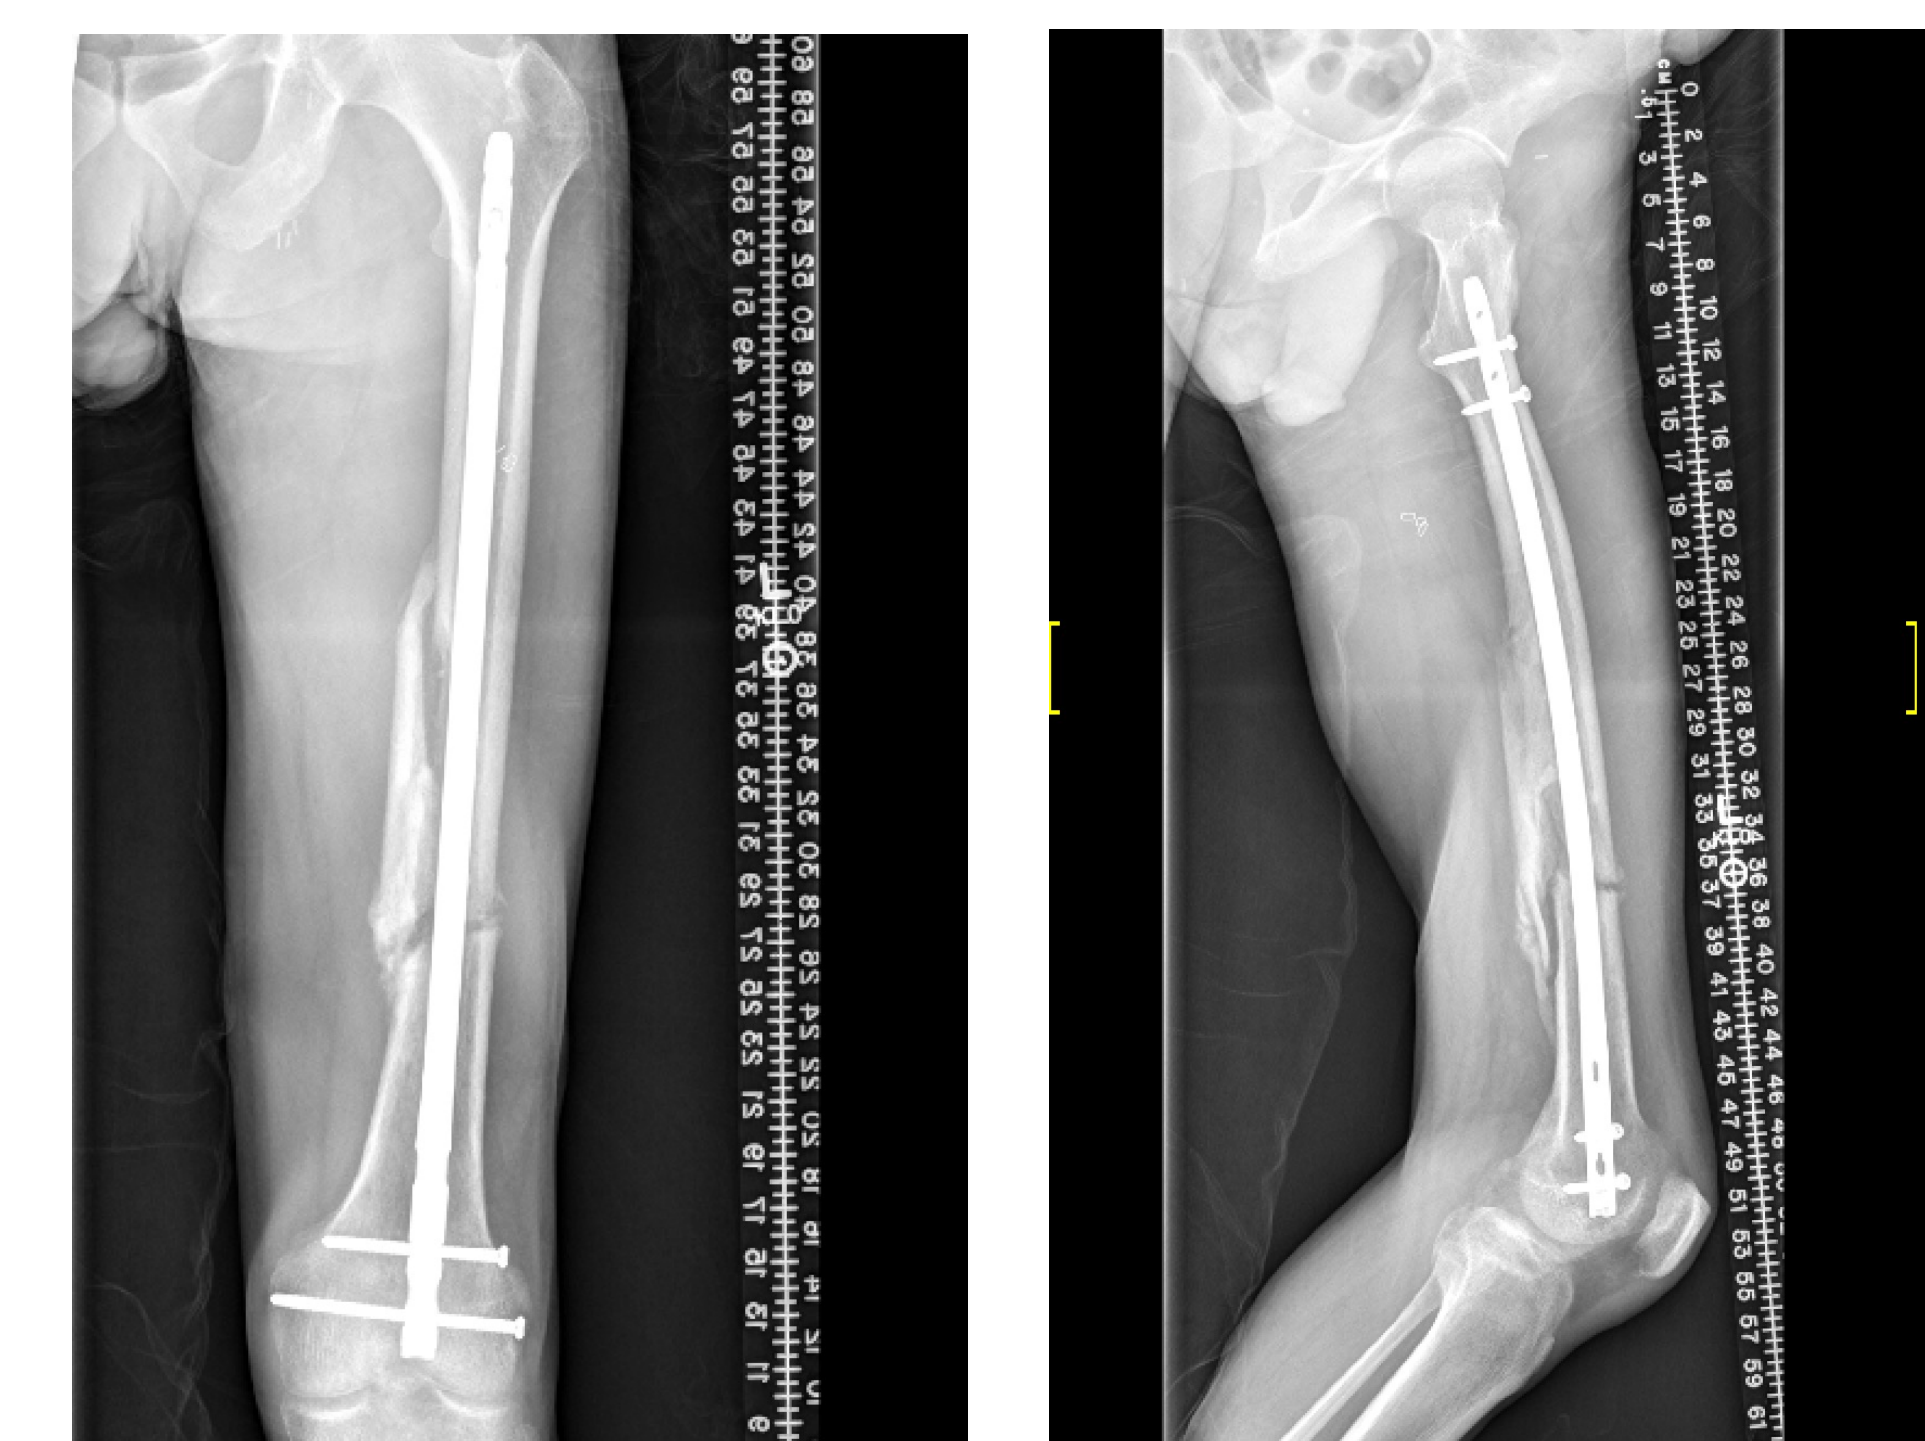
Case example of Lateral and AP radiographs following healing after a femoral shaft fracture with butterfly fragment fixation. mRUST score used to calculate 12 weeks post-operation
